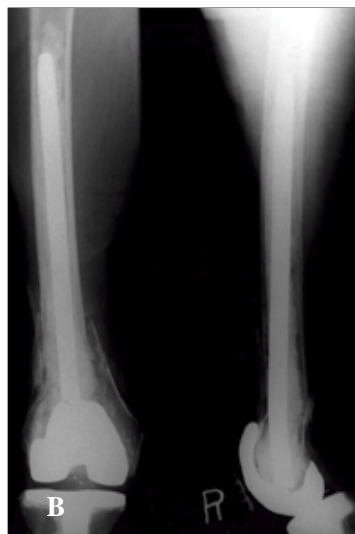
Anteroposterior and lateral radiographs of a 81-year-old female with a supracondylar femur fracture following TKA.
